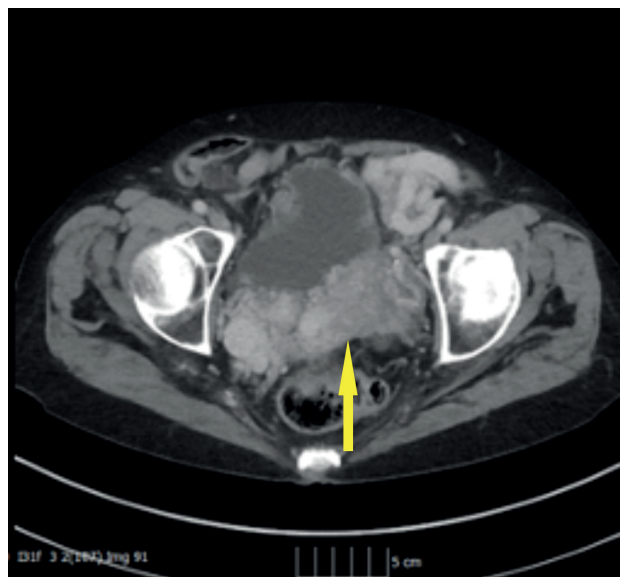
Non-contrast computed tomography in axial plane showing large nidus of arteriovenous malformation posterior to bladder.
